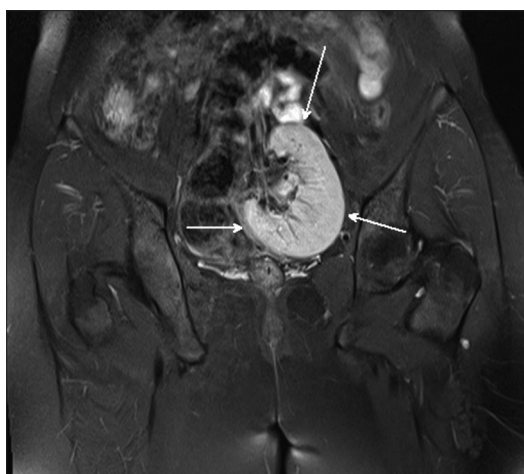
Coronal section magnetic resonance imaging of the pelvis (proton density with fat saturation) shows a left side pancake-shaped kidney. The white arrow shows the ectopic kidney
